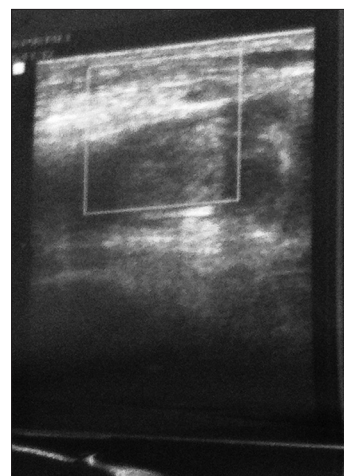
(Case 1) Leg ultrasound showing thrombus in Left saphenofemoral vein
